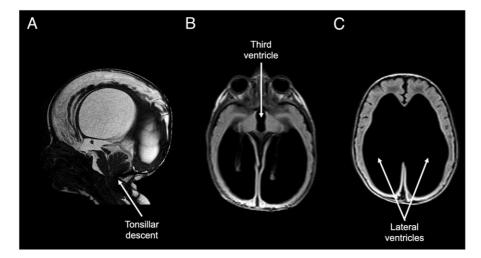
The inferior part of the cerebellum is called the tonsils, and the tonsils can descend downward, creating a Chiari malformation with accompanying hydrocephalus. Magnetic resonance image of a 6-week-old with increasing head circumference demonstrating Chiari type I malformation with a T2-weighted sequence sagittal view showing tonsillar descent below the foramen magnum, a T1-weighted fluid-attenuated inversion recovery (FLAIR) sequence axial view showing a dilated third ventricle (B), and a T1-weighted FLAIR sequence axial view showing enlarged lateral ventricles (C).
